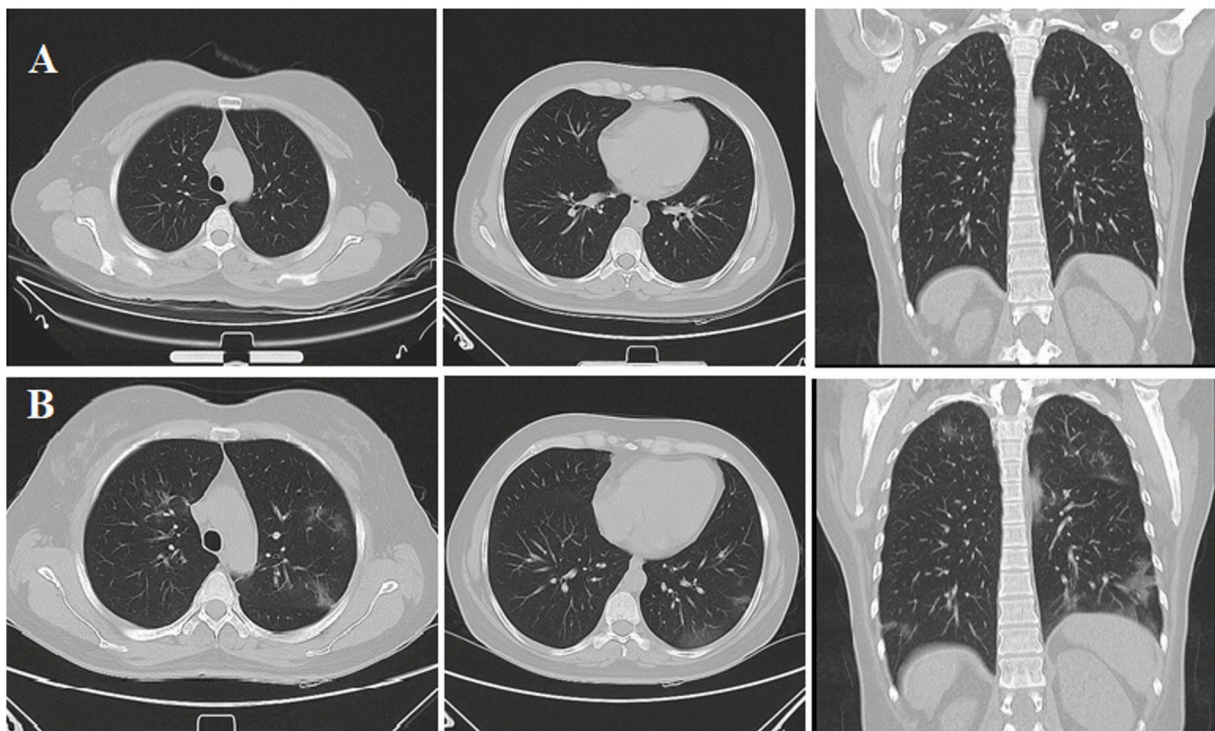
Chest CT-scan during the two episodes of SARS-CoV-2/COVID-19 in our patient. A. First episode, June 30, 2020. B. Second episode, October 10, 2020.
